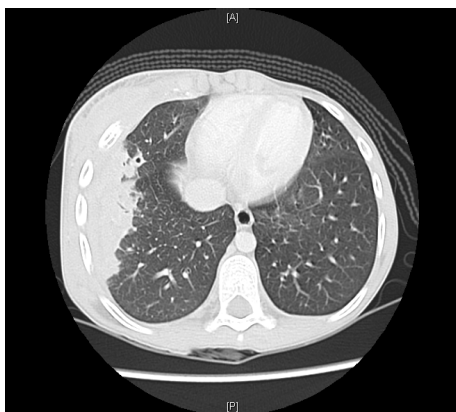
Computed tomography (CT) scan with contrast shows lung parenchyma
